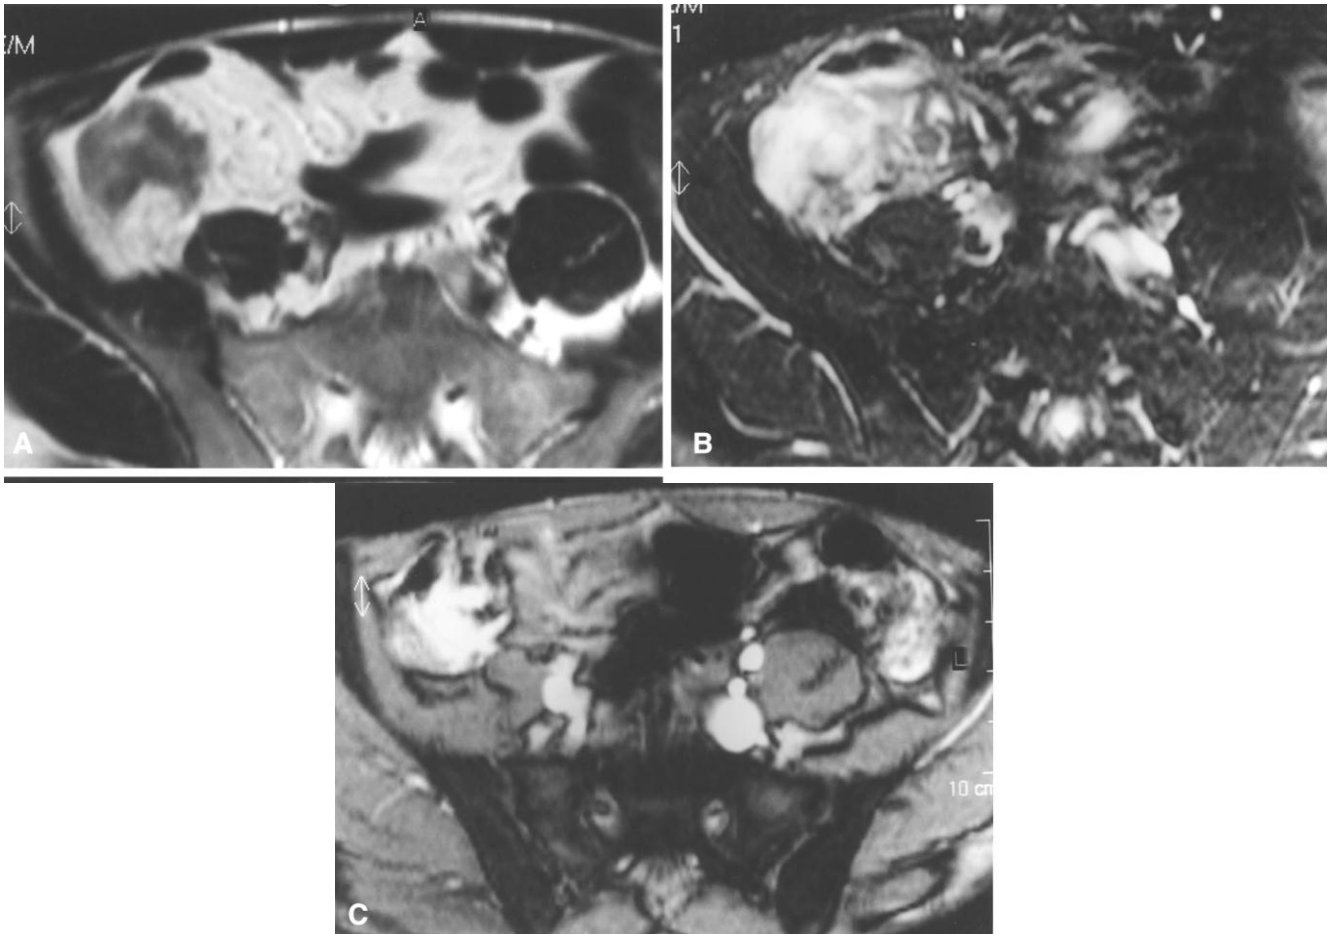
A 36-year-old male with ileocolic CD and clinical signs of activity (erythrocyte sedimentation rate 55, white blood cell count 9000/mm³). A Axial T2-weighted TSE image demonstrates wall thickening of the cecum and last ileal loop. B Axial T2-weighted fat suppressed TSE image shows marked hyperintensity of the bowel wall and adjacent fat tissue, indicating active disease. C Axial breath-hold T1-weighted TFE image obtained after intravenous injection of gadolinium shows marked mural enhancement of the cecum and ileocecal valve.
